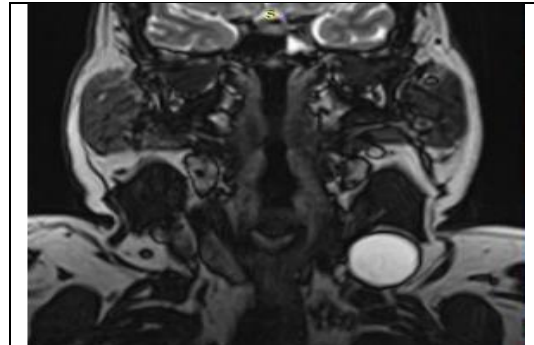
T2-weighted magnetic resonance imaging with high signal intensity.
